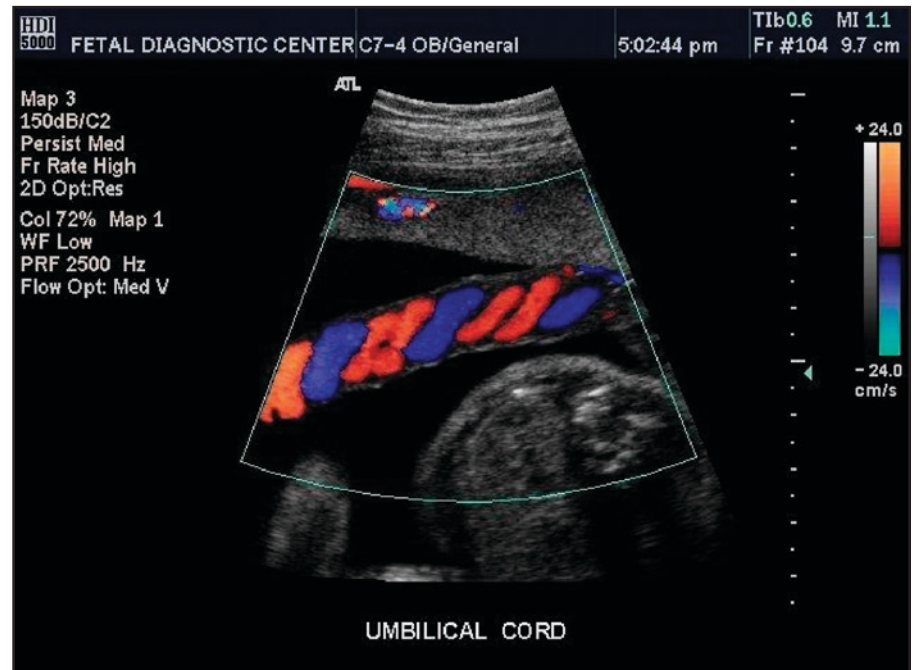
Sonogram with color Doppler of a normal 3-vessel umbilical cord showing its rope-like appearance. Image courtesy of Virlene Guzman, RDMS.
